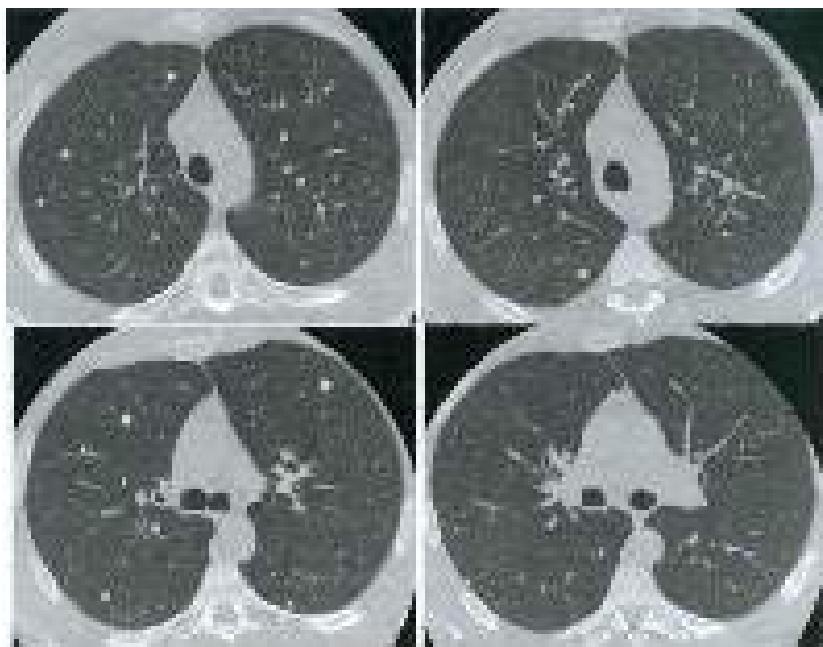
Condition 6 months after pneumonia that complicated varicella in an HIV-infected patient. HRCT. Both lungs demonstrate chaotically distributed multiple focal opacities up to 5 mm in diameter, some of which contain centrally located calcifications, while others are completely calcified.
